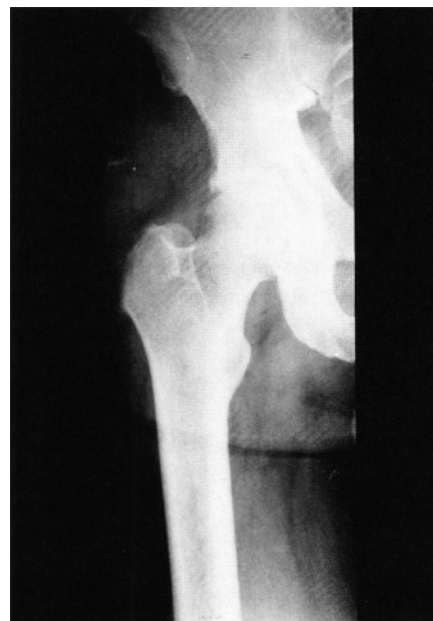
Plain film radiograph revealing a soft tissue mass with microcalcification.
